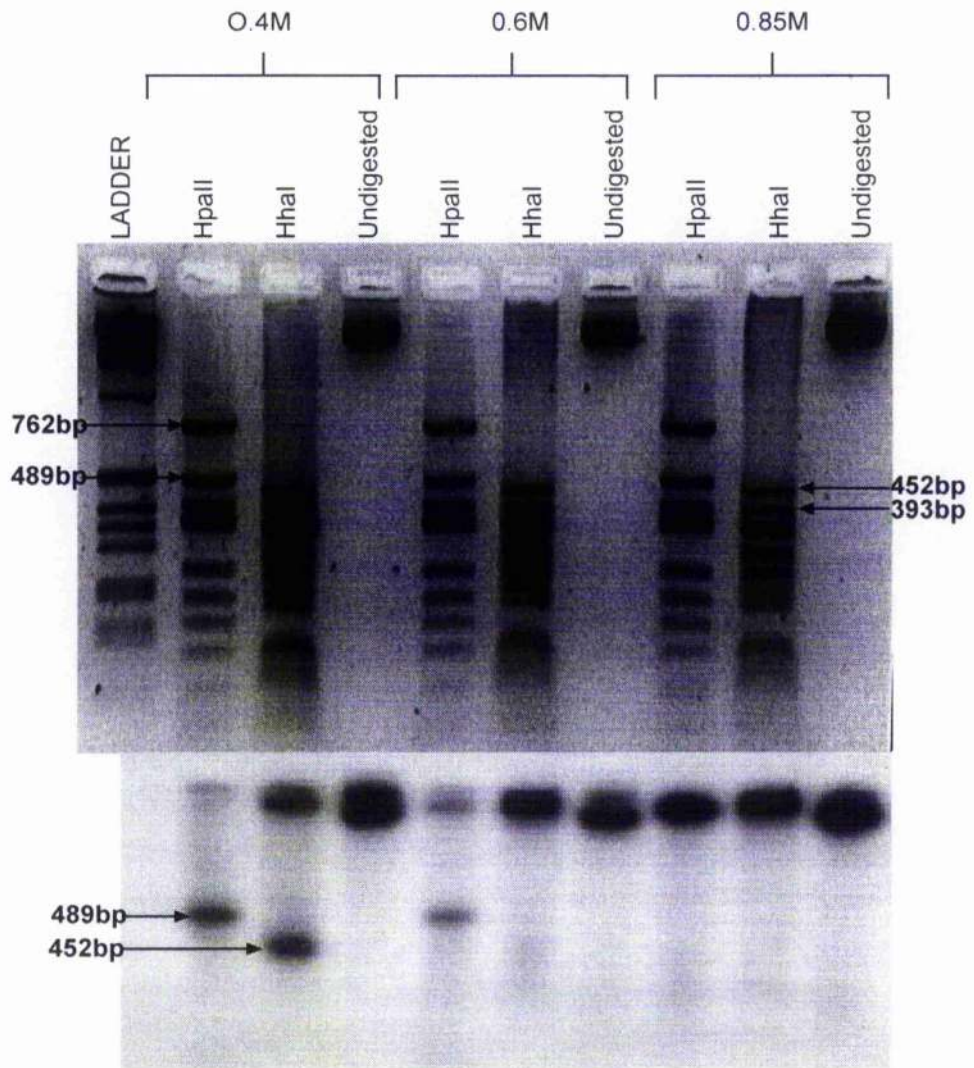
Separation of Unmethylated, Partially methylated and Densely Methylated pTEST Plasmid on the HMBD Column Plasmids were modified as described in the main text, endlabeledled with dCTP mixed, loaded on to the HMBD column and fractions were collected over a NaCl gradient. The salt fractions are indicated above each lane. Following the collection of each fraction the DNA was precipitated, resuspended and 1ug of unmethylated unlabelled pGem-test plasmid was added to each fraction. The fractions were then digested with HpaII and HhaI: both enzymes will cut the unmethylated plasmid, HpaII will cut partially methylated plasmid, and neither will cut the densely methylated plasmid. The upper gel is the agarose gel digest of the fractions. Only the unmethylated plasmid spike can be seen; the labelled plasmids fall below the mass required to be visible on an agarose gel. It can be seen from this gel that the restriction digests proceeded to completion and none were inhibited. The lower picture is an autoradiograph of the the agarose gel after it was dried and incubated at -80oC with the radiographic film for 48hours. This autoraiograph demonstratres that there is unmethylated plasmid (digested by both HpaII and HhaI) in the low salt fraction, partially methylated plasmid (digested by HpaII, but not HhaI) in the medium salt fraction and densely methylated plasmid (resistant to digestion by either enzyme) in the high salt fraction. It can be concluded that this HMBD column binds and separates DNA on the basis of methylation density.
